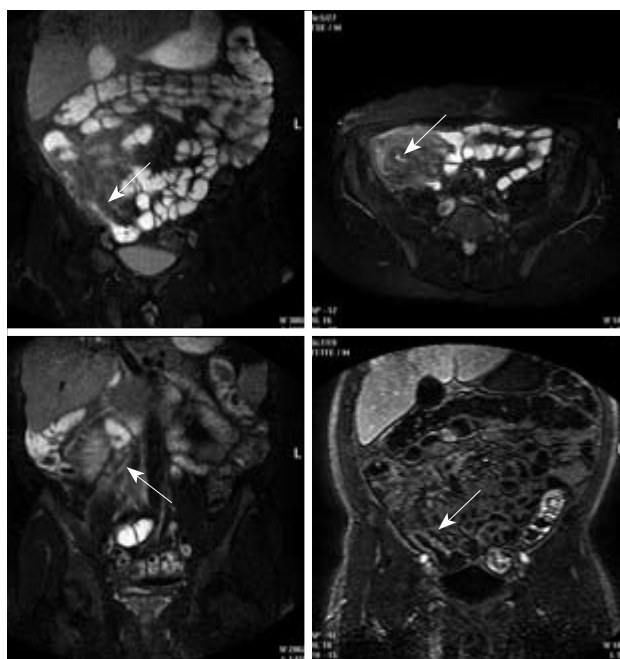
MRI of Crohn's disease. The coronal and axial (upper panel) fat-saturated T2-weighted MRI display marked wall thickening, mucosal irregularity and stenosis of the terminal ileum (arrows). Advanced mesenteric inflammation with hypervascularity and enlarged lymph nodes (arrow) are visualised on coronal fat-saturated T2-weighted MRI (lower left). Coronal T1-weighted MRI (lower right) shows clear wall enhancement (arrow). Modified from [36].
